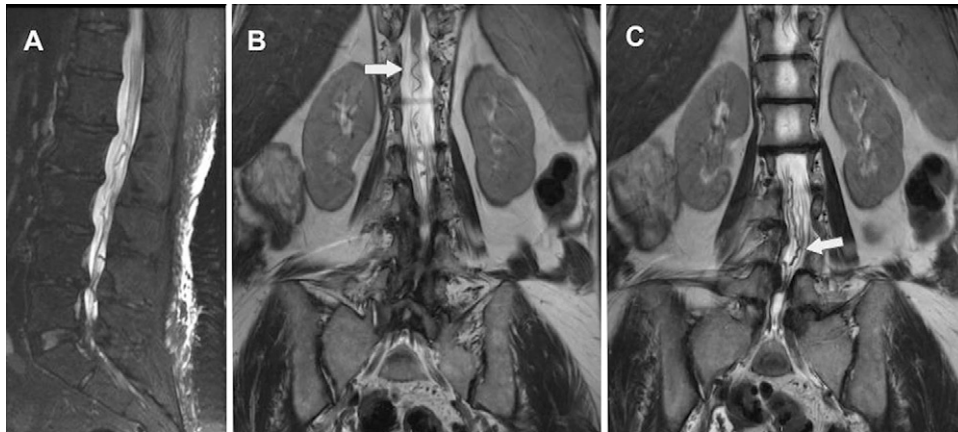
Sagittal (A) and coronal (B and C) T2-weighted MRI showing abnormal serpentine vasculature at the level of the lumbar cistern (white arrows).
